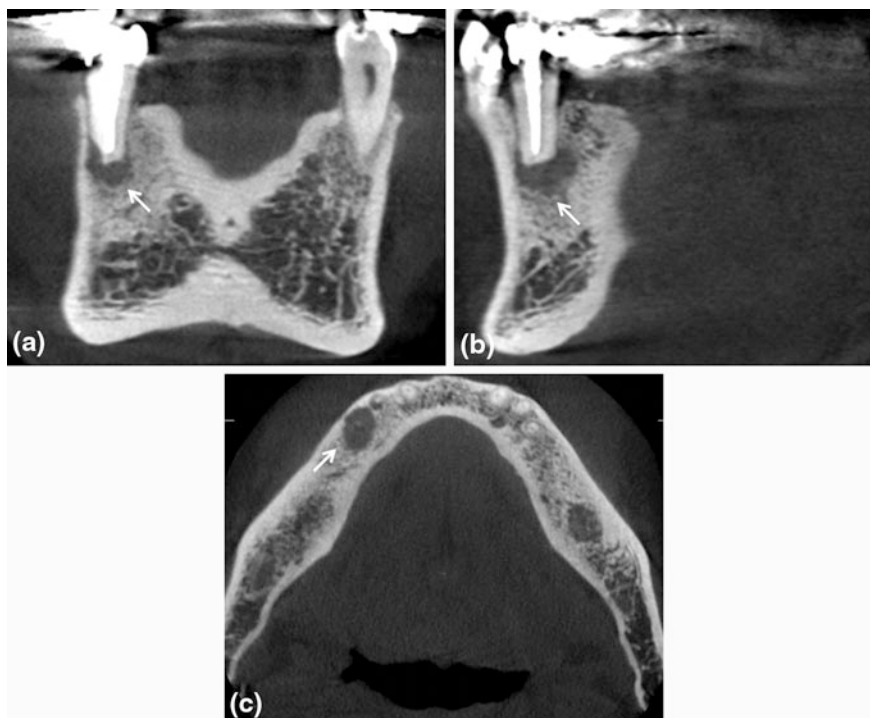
CBCT coronal (a), sagittal (b) and axial (c) sections evidencing an area of low density at the apex of 45 tooth (*thin arrow*). It is a chronic periapical osteoperiostitis, or “halo lesion” determining displacement of the periosteum
